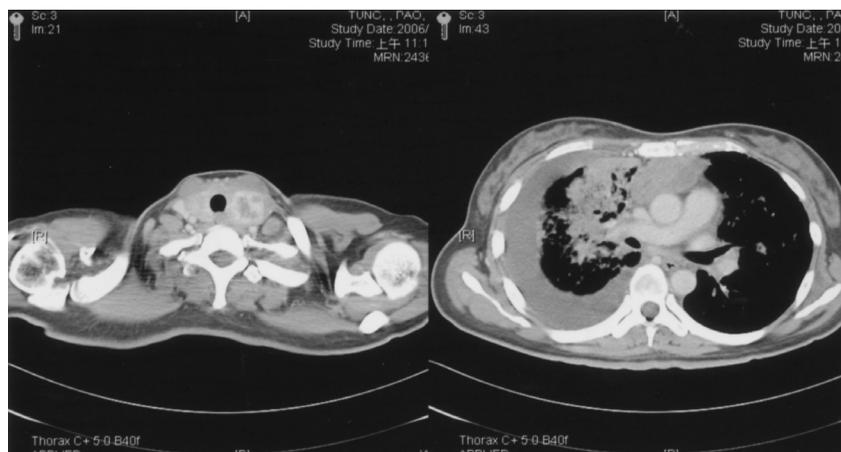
Computed tomography with contrast enhancement of the chest shows a left thyroid goiter of 28 mm in size, right lung infiltration forming consolidation around the hilum, right massive pleural effusion, and numerous miliary nodular lesions at the left lung field.
